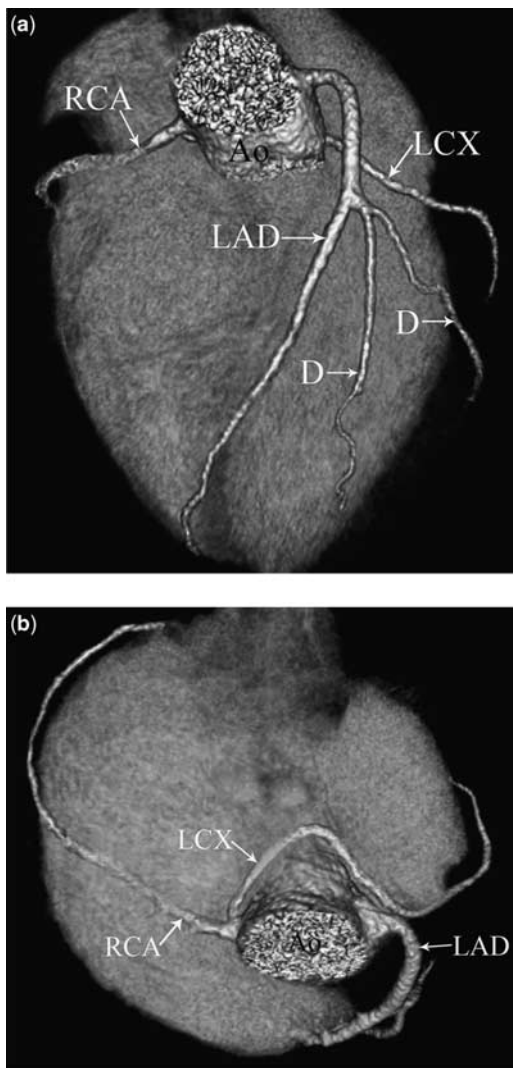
Left circumflex (LCX) artery arising from the right sinus of Valsalva with a retroaortic course in a 42-year-old man. Volume-rendering multidetector computed tomography images (a, b) show the LCX artery arising from the right sinus of Valsalva and coursing posterior to the aorta (Ao) and left anterior descending (LAD) artery originating from a separate orifice of the left sinus of Valsalva. D = diagonal branches; RCA = right coronary artery.
